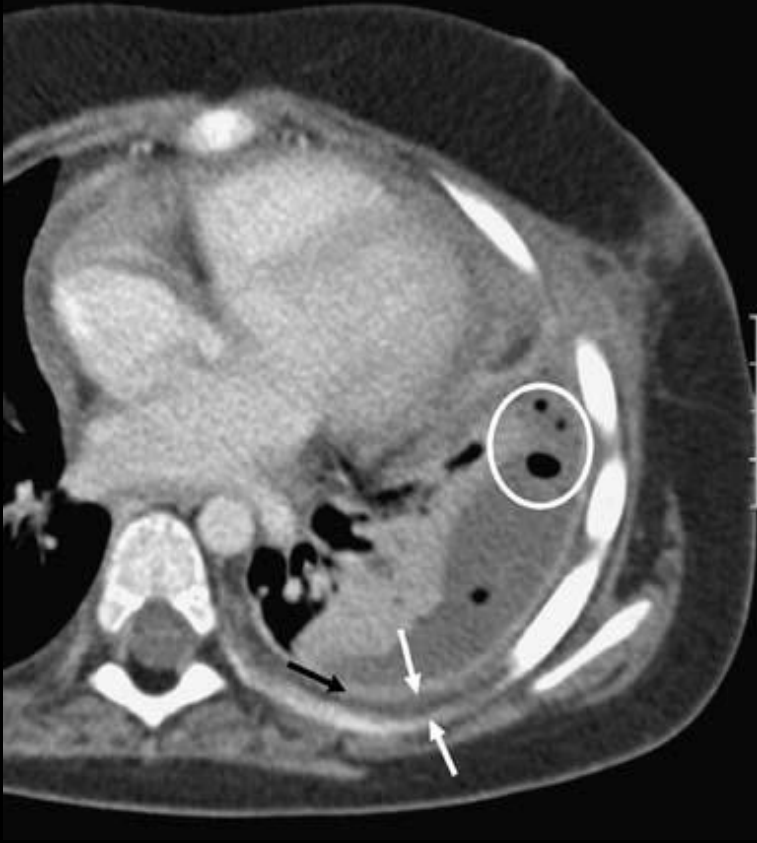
CT features of complicated PPE. Contrast-enhanced axial CT image of the thorax in a child following failed drainage of a left-sided empyema. There is thickening and enhancement of the parietal pleura (black arrow), thickening and increased density of the subcostal fat (white arrows), and an internally convex pleural fluid collection containing bubbles of gas, indicating the presence of septations (circled)
